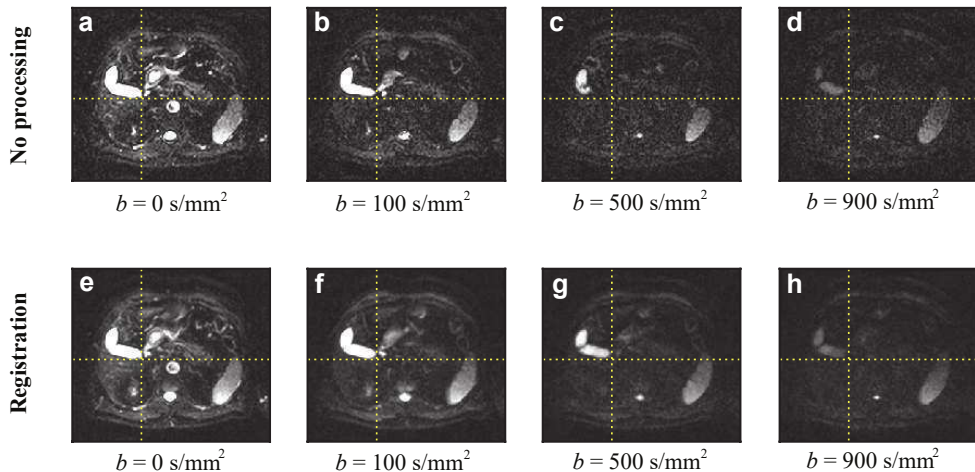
Examples of different b-value DW-MR images in the ‘no processing’ and ‘image registration’ scenarios (volunteer 5, first visit). The $b = 100$ s/mm², $b = 500$ s/mm² and $b = 900$ s/mm² images (diffusion gradient direction x) are more similar to the $b = 0$ s/mm² image in the ‘image registration’ scenario. The mutual information metric used for registration handles the differences in intensity distribution between the images.
